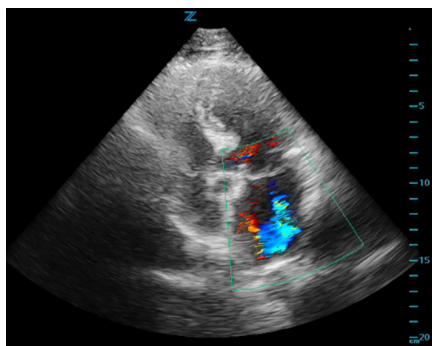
Ultrasound image of the cardiac apical four chamber view demonstrating mitral valve regurgitation with color flow Doppler.
